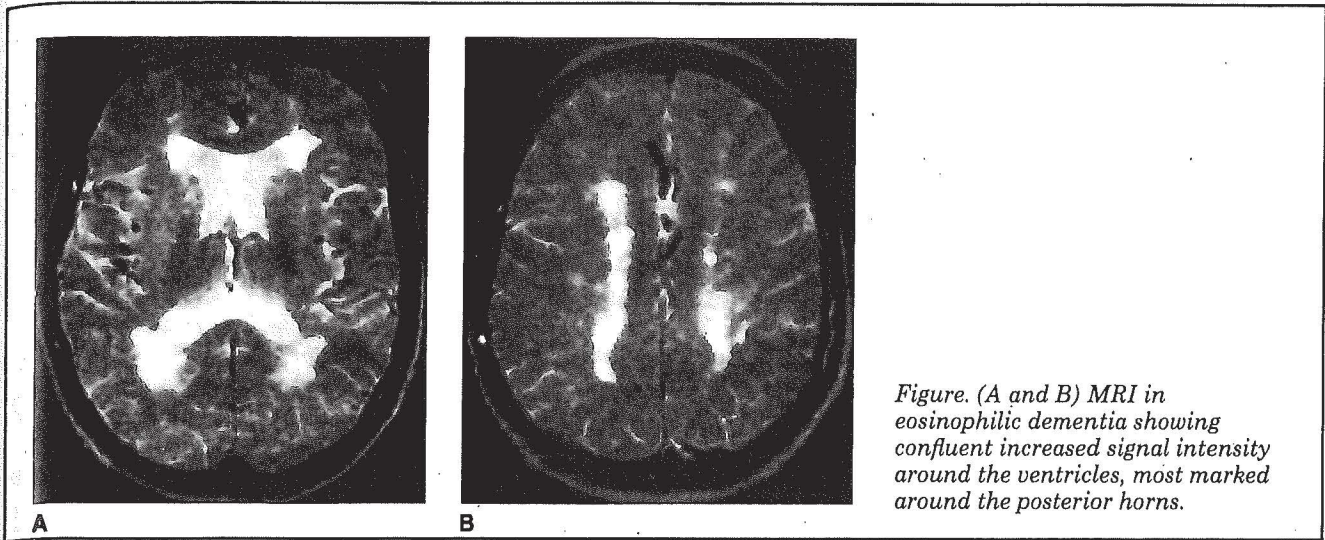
(A and B) MRI in eosinophilic dementia showing confluent increased signal intensity around the ventricles, most marked around the posterior horns.
